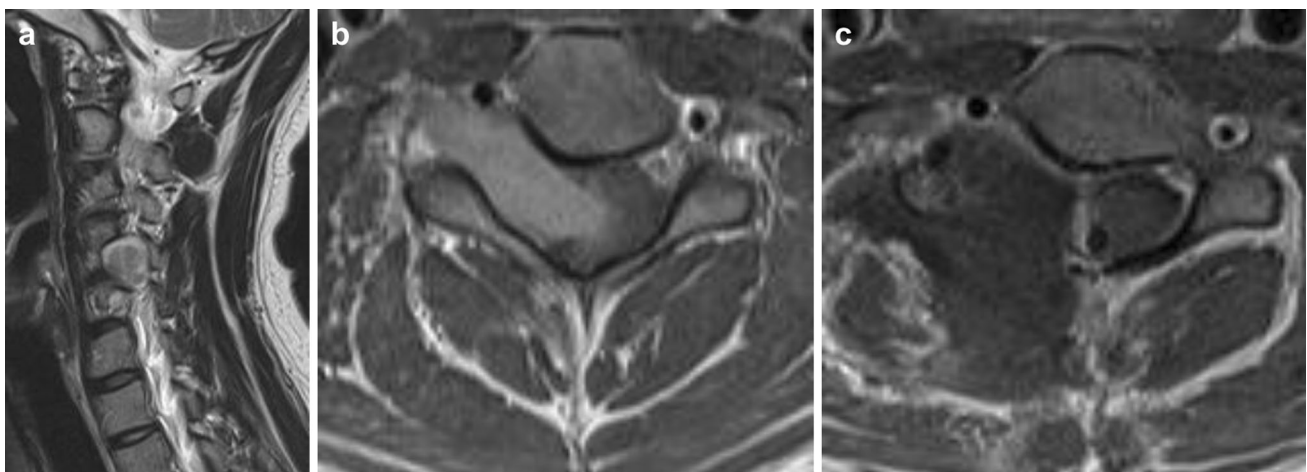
A 25-year-old male patient complained of lower extremity weakness. a T2-weighted sagittal magnetic resonance imaging (MRI) shows an extraforaminal round shaped tumor at the C4–5 level. b T1-weighted axial MRI with enhancement shows a dumbbell-shaped
